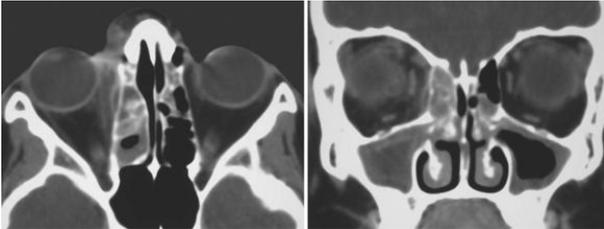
CT scan of orbit & PNS (axial & coronal slices) diffuse inflammatory changes are noted in maxillary & ethmoid sinuses, predominantly on right side, extending in to right orbit with inflamed medial rectus muscle.
